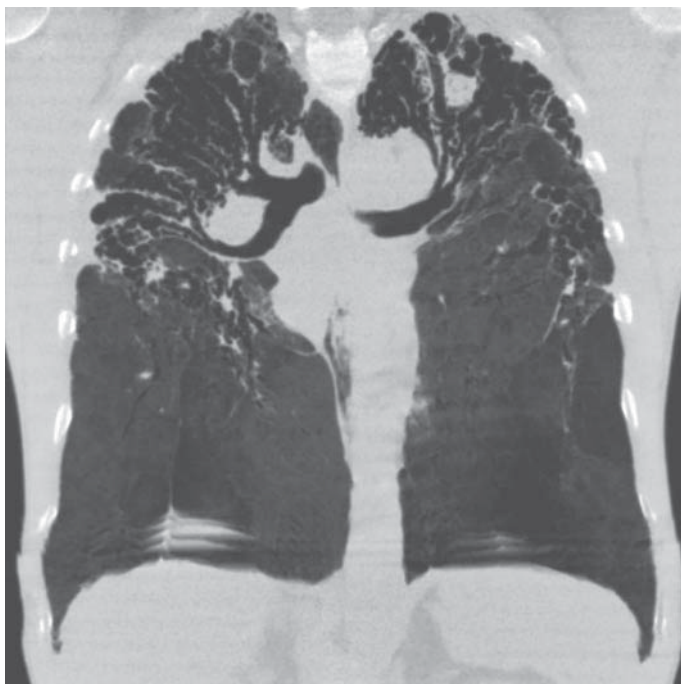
Coronal high-resolution computed tomography scan of the thorax of a sarcoidosis patients with severe advanced fibrosis, especially in the upper lobes (minimal intensity projection image).
